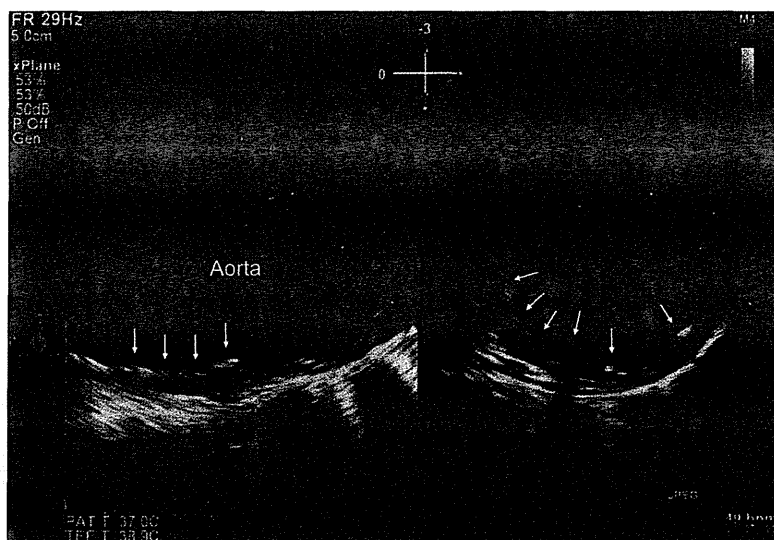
Transesophageal echocardiography (TEE) images of complex aortic plaques in a nonvalvular atrial fibrillation (NVAF) patient with a CHADS₂ score of 4. Simultaneous multi-plane imaging by real-time 3-D TEE provided both long-axis view (*left panel*) and short-axis view (*right panel*) of the aortic arch and showed large plaques with ulcerations (*arrows*).
